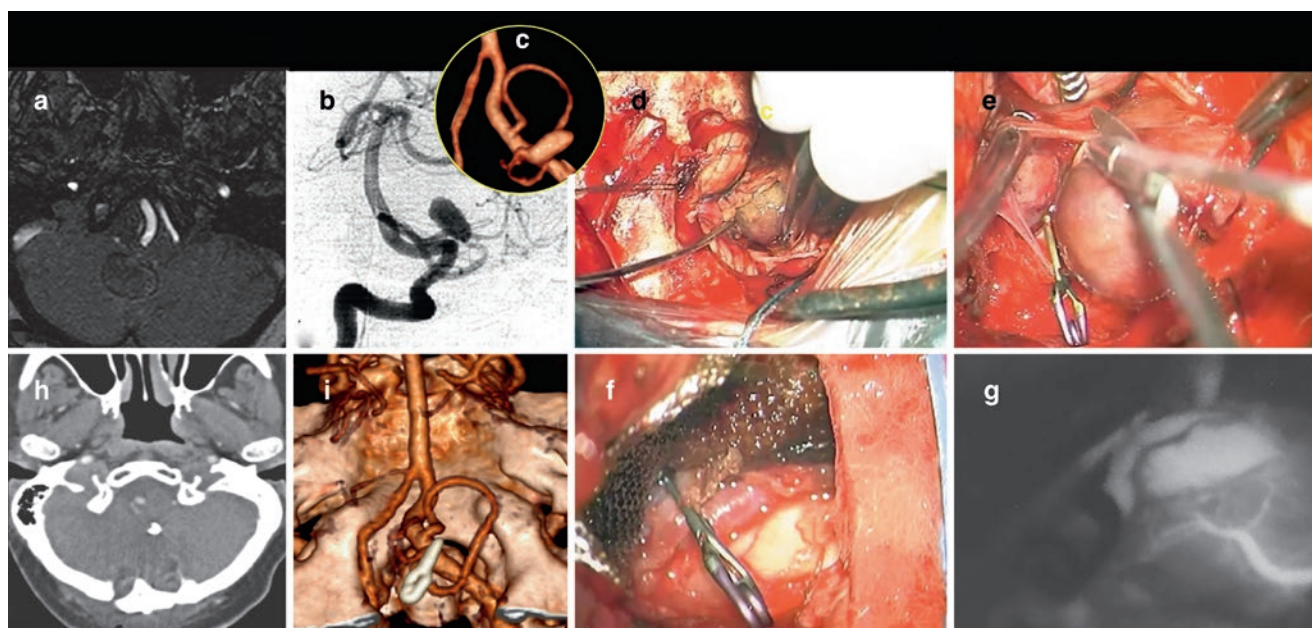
MRI angiography showing a giant thrombosed aneurysm causing a right cerebellar compression (a). CT angiography and DSA demonstrating the involvement of the distal PICA (b, c). Median suboccipital approach, exposure of the thrombosed aneurysm, dissection, clipping
